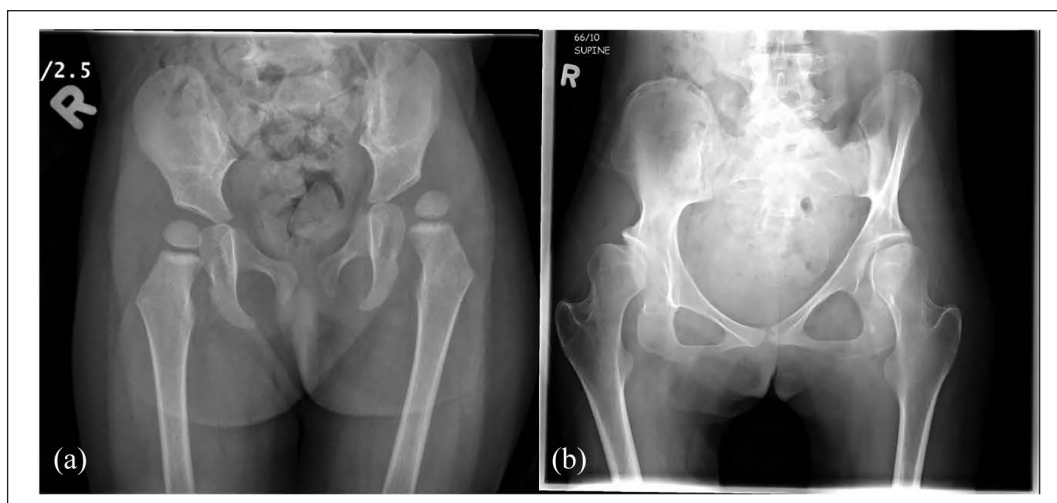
Radiographs used to list and rank radiographic parameters (qualitative or quantitative) for documentation, management, or treatment decision-making in (a) skeletally immature and (b) skeletally mature child.
